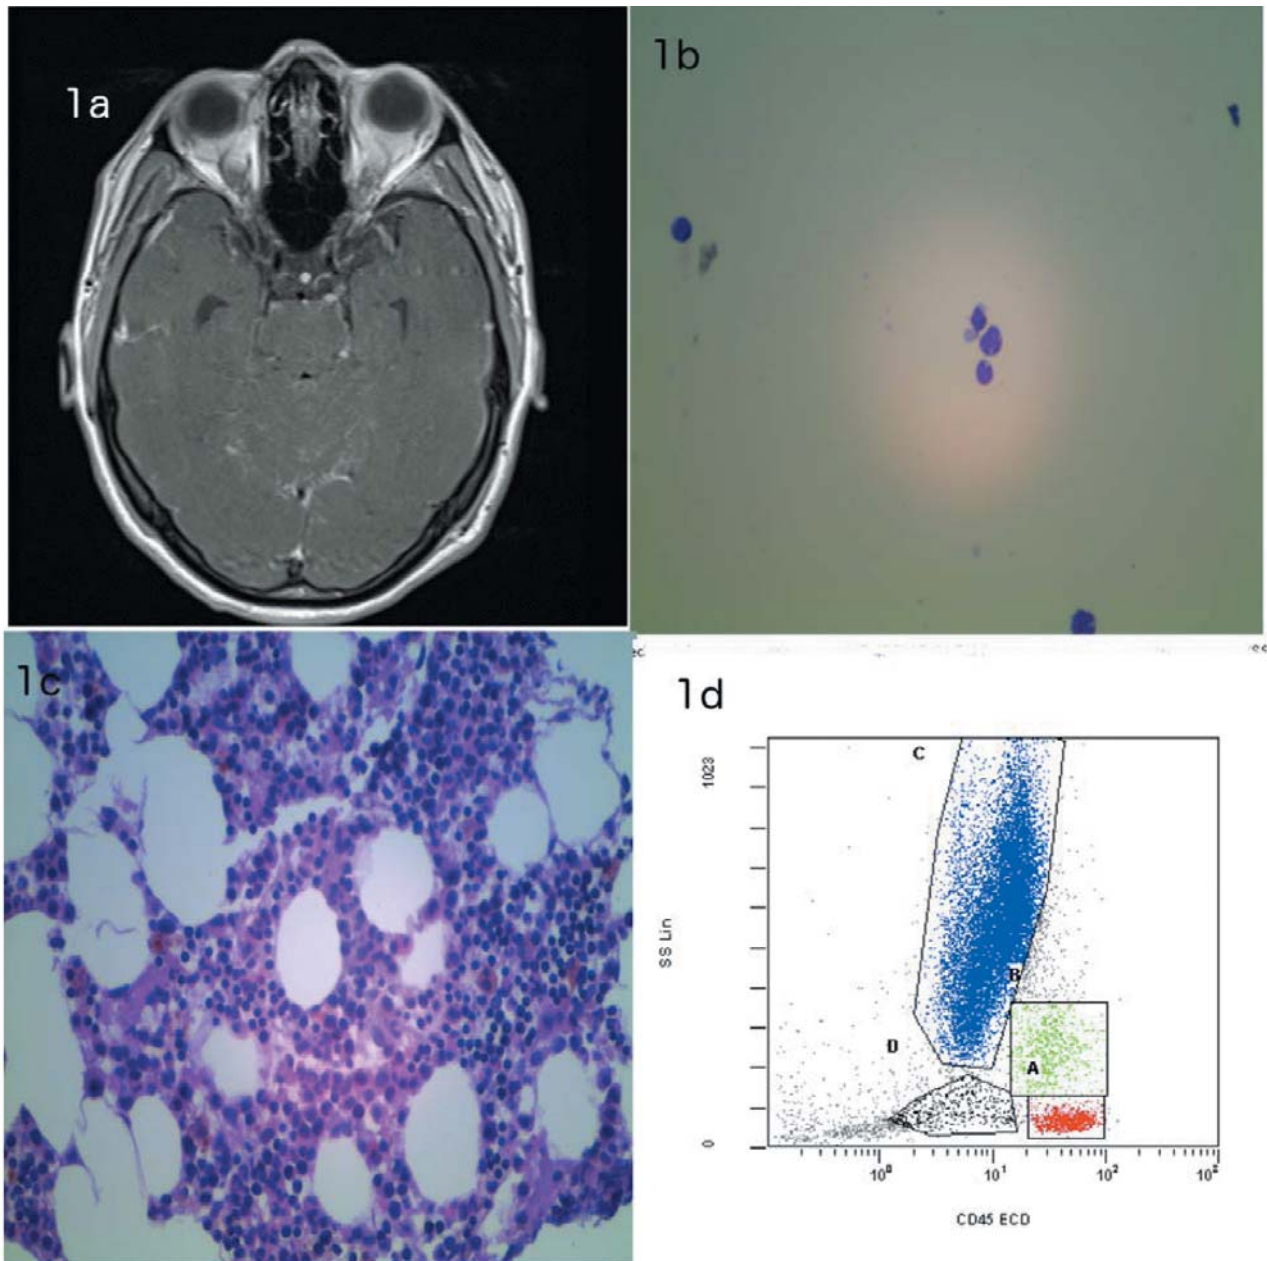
a: Brain magnetic resonance imaging showing leptomeningeal enhancement. b: Cerebrospinal fluid cytology showing leukemia blasts. c and d: Normal bone marrow with no increase in blasts.*
